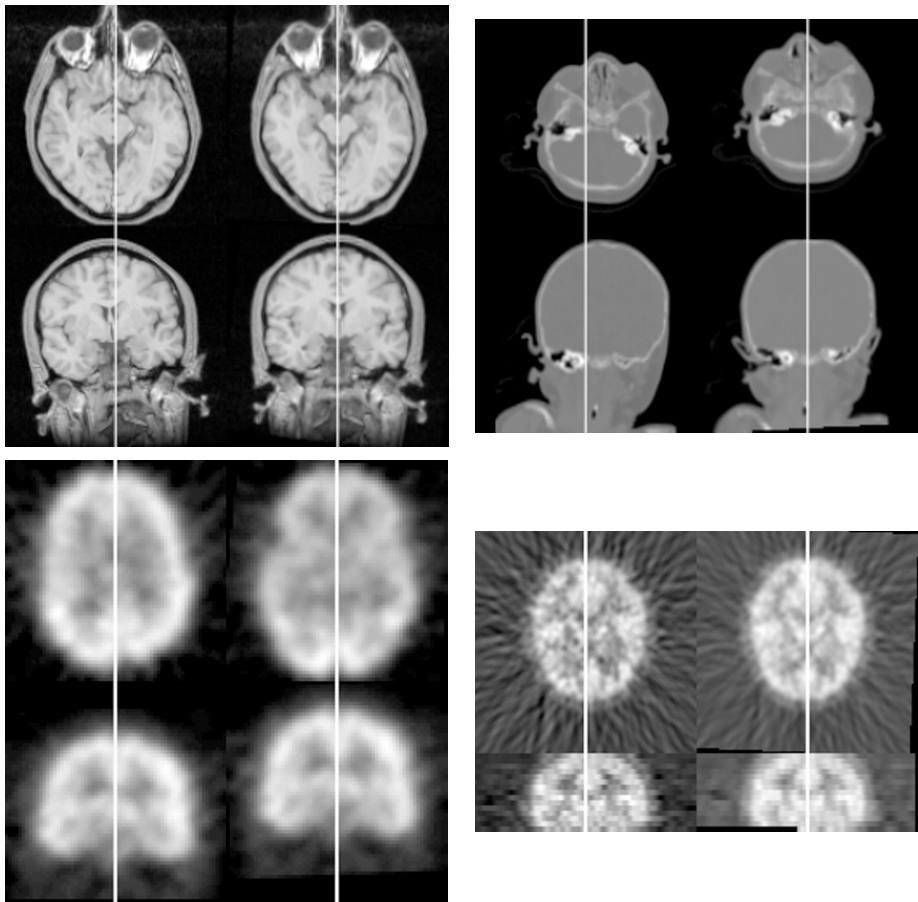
Results on real images. From left to right, top to bottom: isotropic MR, CT, SPECT images, and anisotropic PET image. See Section 4 for details.
